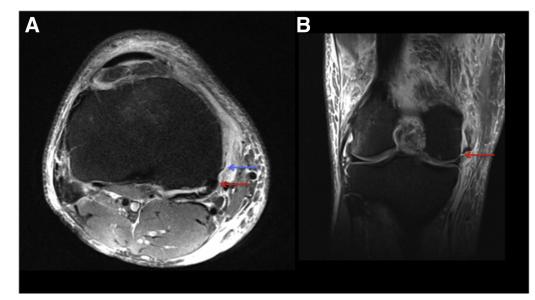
Imaging of injuries to the posteromedial capsule (PMC) is challenging, and anteromedial rotatory instability remains mainly a clinical diagnosis. Particularly in an acute injury, magnetic resonance imaging (MRI) is helpful in diagnosis of injuries to the PMC as a thorough clinical examination in the office is often difficult due to patient guarding. (A) Axial T2-weighted MRI showing edema and possible tibial detachment of the POL (blue arrow) with the semimembranosus tendon (red arrow) seemingly intact. (B) Coronal T2-weighted MRI demonstrating edema of the PMC and injury to the meniscofemoral connections of the posterior oblique ligament (red arrow).
